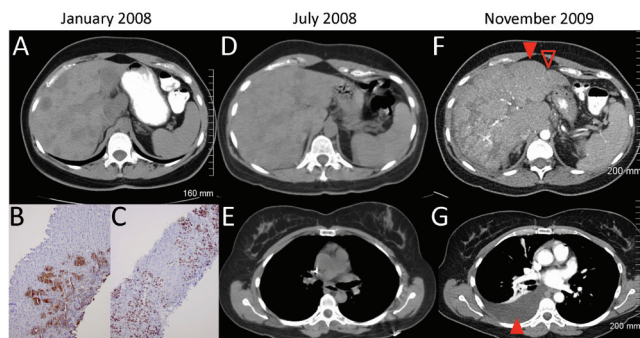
In January 2008, (A) abdominal computed tomography (CT) scan demonstrated hepatic hypodensities, and biopsy of a liver lesion was positive for (B) calcitonin and (C) thyroid transcription factor 1, confirming the diagnosis of metastatic medullary thyroid cancer. In July 2008, FOLFOX chemotherapy (5-fluorouracil–leucovorin–oxaliplatin) was discontinued, and the patient was maintained on sunitinib after (D) tumor regression. In November 2009, CT imaging after complaints of abdominal bloating, early satiety, and right upper quadrant pain demonstrated (F) a cirrhotic-appearing liver with a nodular surface (closed arrowhead) and capsular retraction (open arrowhead). The patient also developed (G) a pleural effusion (arrowhead) that was not present on earlier imaging (E).
